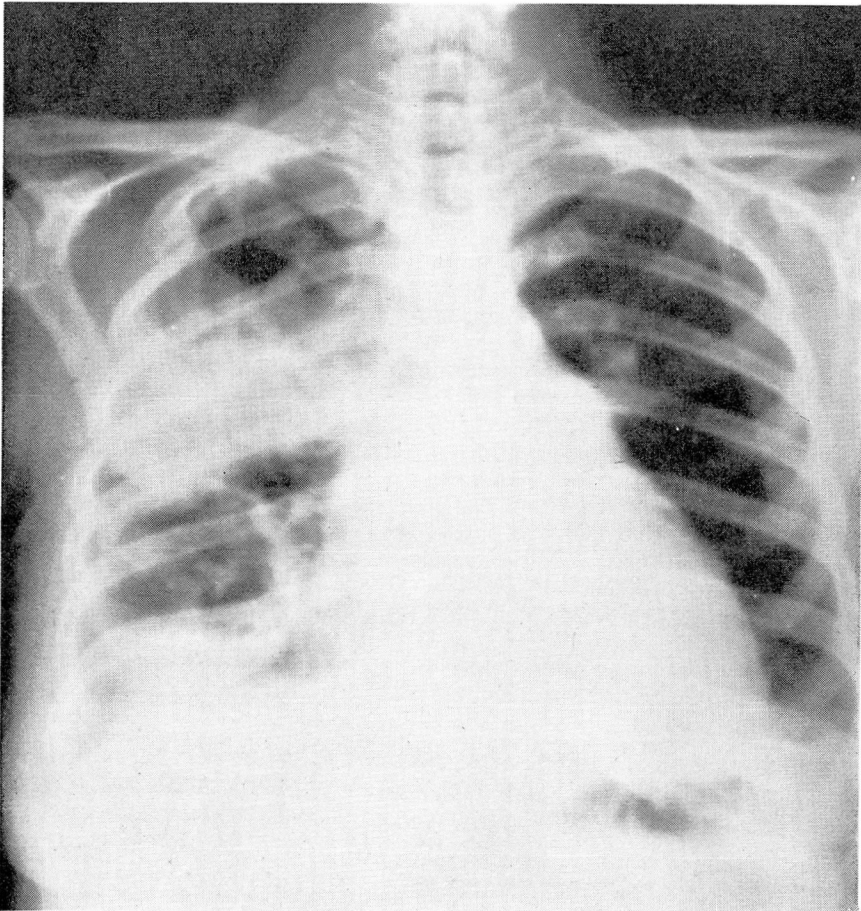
Roentgenogram of the chest showing large cavities in the right lung. These proved to be abscesses caused by ischemic necrosis.
